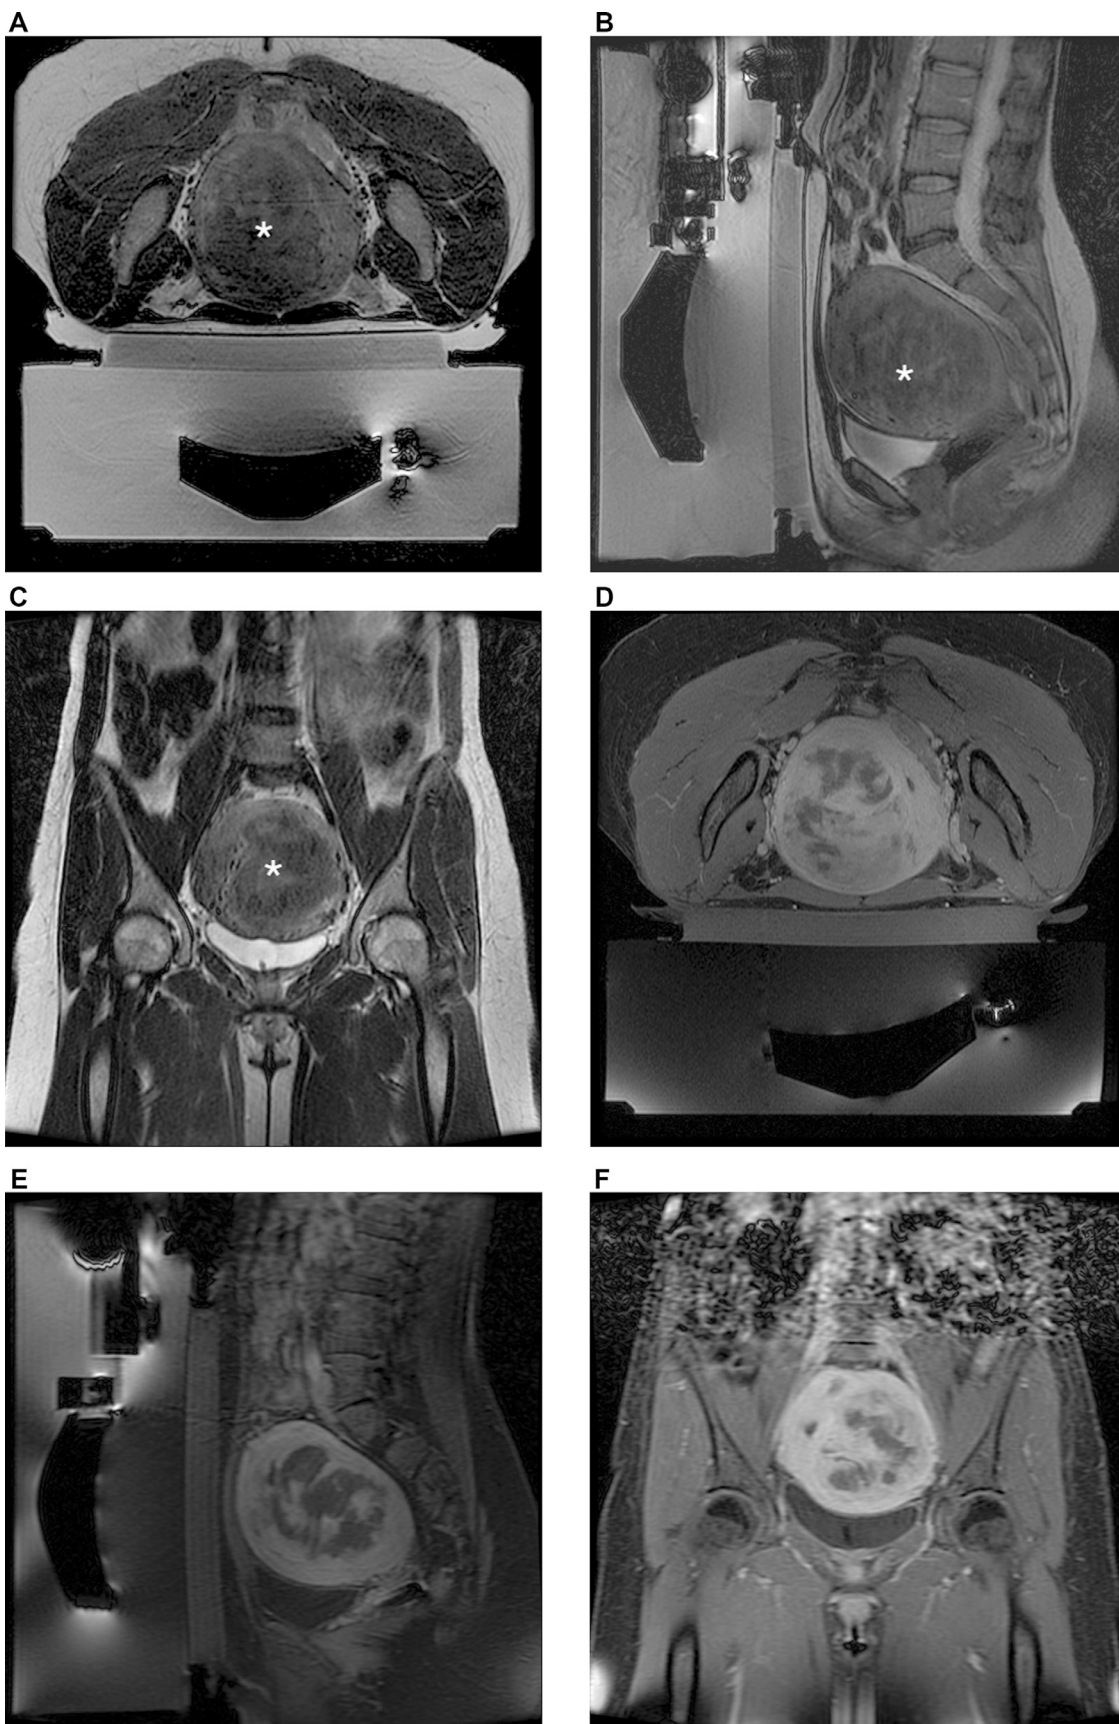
Axial (A), sagittal (B) and coronal (C) pretreatment T2-weighted images of a big (about 8 cm) intramural fibroid (*white star*). The patient underwent MRgFUS. However the treatment was interrupted, due to the prolonged time required (the procedure lasted about 3 hours) and the proximity to structures such as bowel loops and sacral bone. Axial (D), sagittal (E) and coronal (F) postcontrast T1 fat-sat images acquired immediately after treatment show only a partial devascularization of the lesion.
